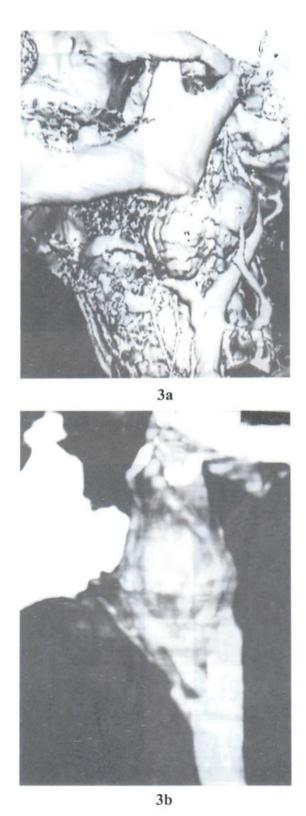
Three dimensional image reconstructions of helical CT; SSD (Fig. 3a), MIP (Fig. 3b) Nicely shown bilateral carotid bifurcation masses, LT.mass (a.) and Rt. Mass (b.) with splaying of ECA from ICA at the carotid bifurcation
